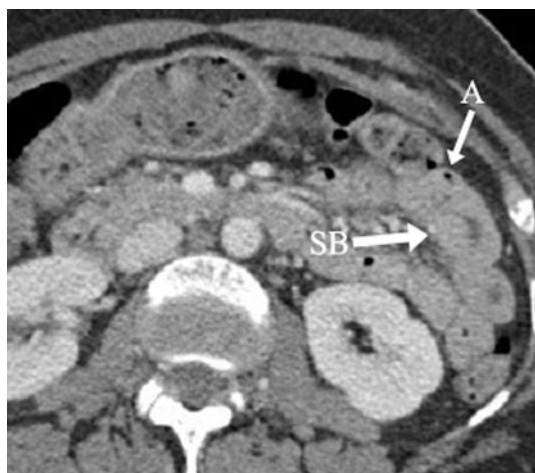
A 43-year-old female status post-blunt abdominal trauma. Axial contrast-enhanced CT of the abdomen demonstrated a loop of small bowel (SB) with apparent wall thickening. However, in the nondependent portion of the bowel, there was an air locule demarcating the thin wall of the bowel (A). Therefore, the loop of small bowel has a normal wall thickness.
